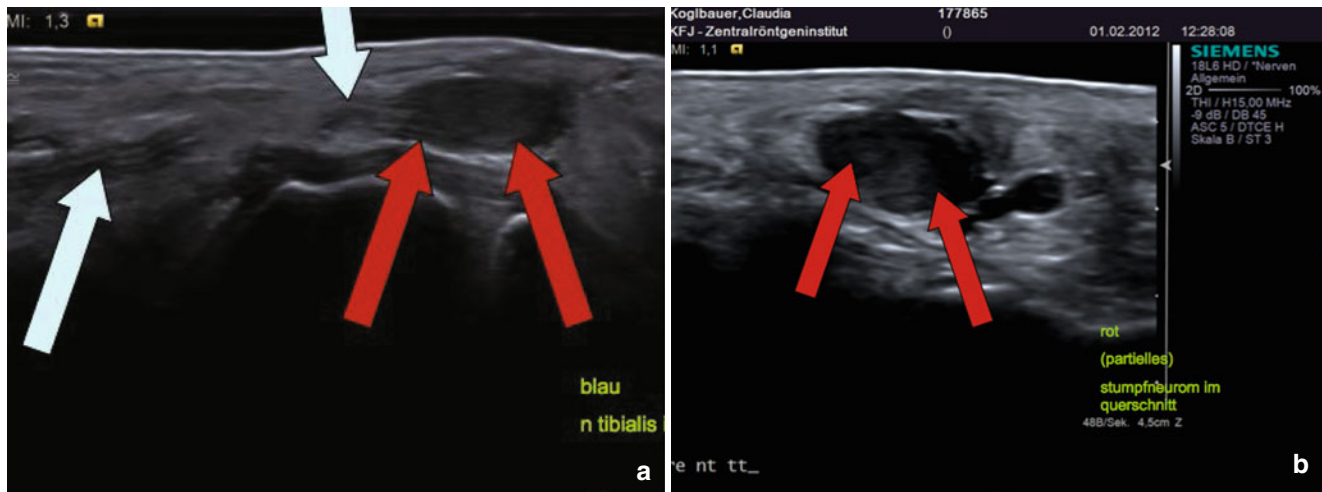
Tibial nerve neuroma in ultrasound: (a) Tibial nerve in the tarsal tunnel (blue arrows). Red arrows (a, b) reveal neuroma of the tibial nerve distal to the tarsal tunnel
